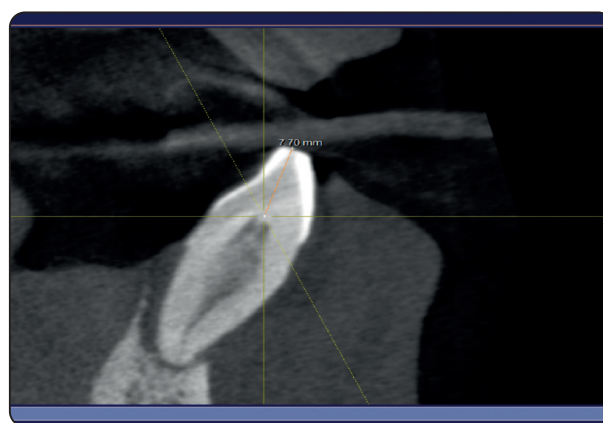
CBCT coronal cut showing the tracing line used from reference point to coronal part of the canal .
